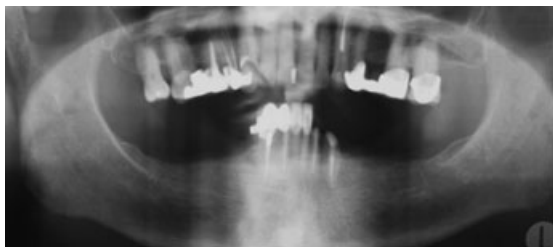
Preoperative panoramic radiograph demonstrated adequate periodontal support for the mandibular anterior teeth; most of the anterior teeth were endodontically treated. If the teeth were to be extracted, completely edentulous criteria of the PDI placed the mandibular arch in Class I.
